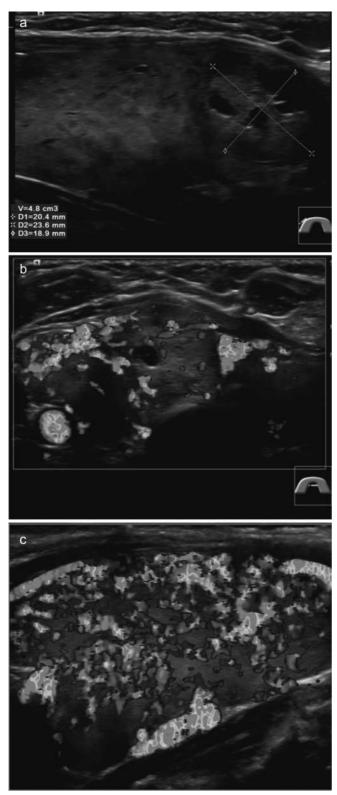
Thyroid ultrasound scans in April 2016. Heterogenic echotexture of parenchyma with small hypoechogenic areas (a), diffusely increased vascularity on Color-Doppler examination (c), complex solid and cystic lesion in the right thyroid lobe with a peripheral-central flow pattern (a, b)
